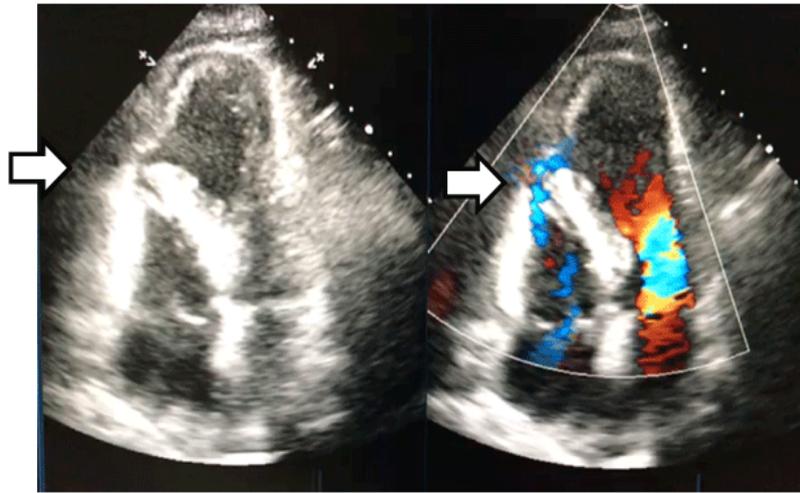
Four-chamber echocardiogram view. The arrows indicate the site of septal rupture
